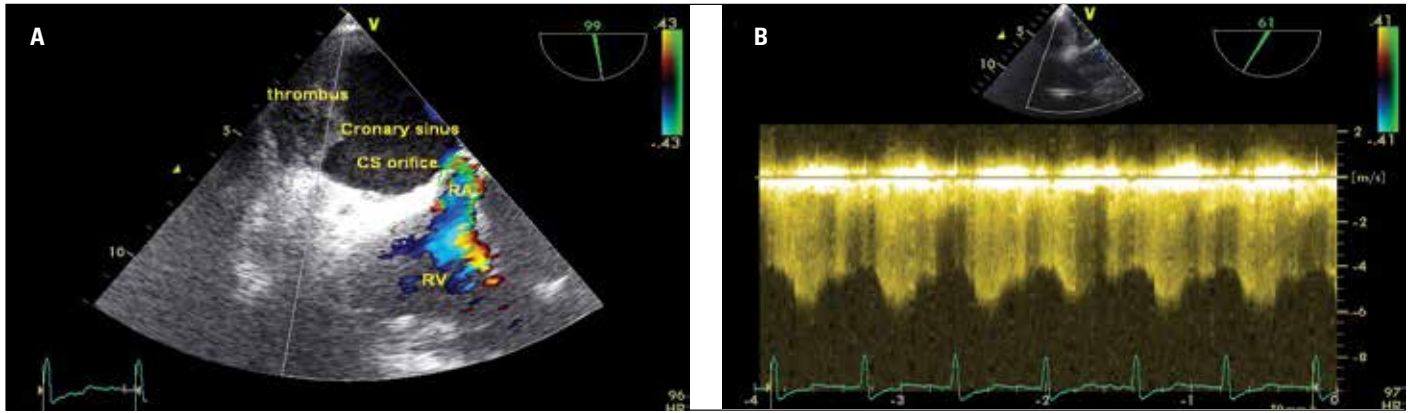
Transesophageal echocardiographic images: showing aneurysmal dilatation of the coronary sinus (CS), which is partially occluded by the thrombus and significant stenosis of its orifice with turbulent flow is seen (A). Continuous wave Doppler showed high velocity continuous Doppler signal (B)
